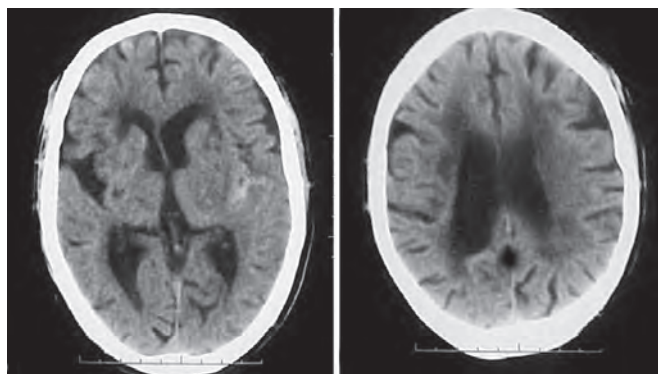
CT diagnosis of a case of normal pressure hydrocephalus
